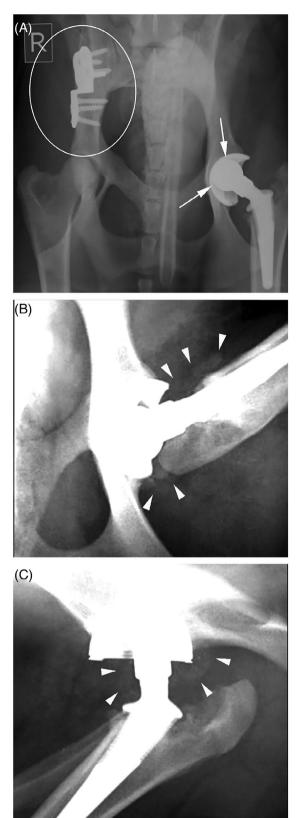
Radiographic images of the pelvis. A, Ventrodorsal extended view shows DPO (double pelvic osteotomy) plates (white circle) on the right ilium, asymmetrical position of the femoral head prosthesis within the acetabular cup (long arrows). B, C, Ventrodorsal frog-leg and mediolateral views magnified on the left hip joint showing the amorphous mineral opacities surrounding the prosthetic implant and hip joint, consistent with the "cloud sign" (white arrowheads).
